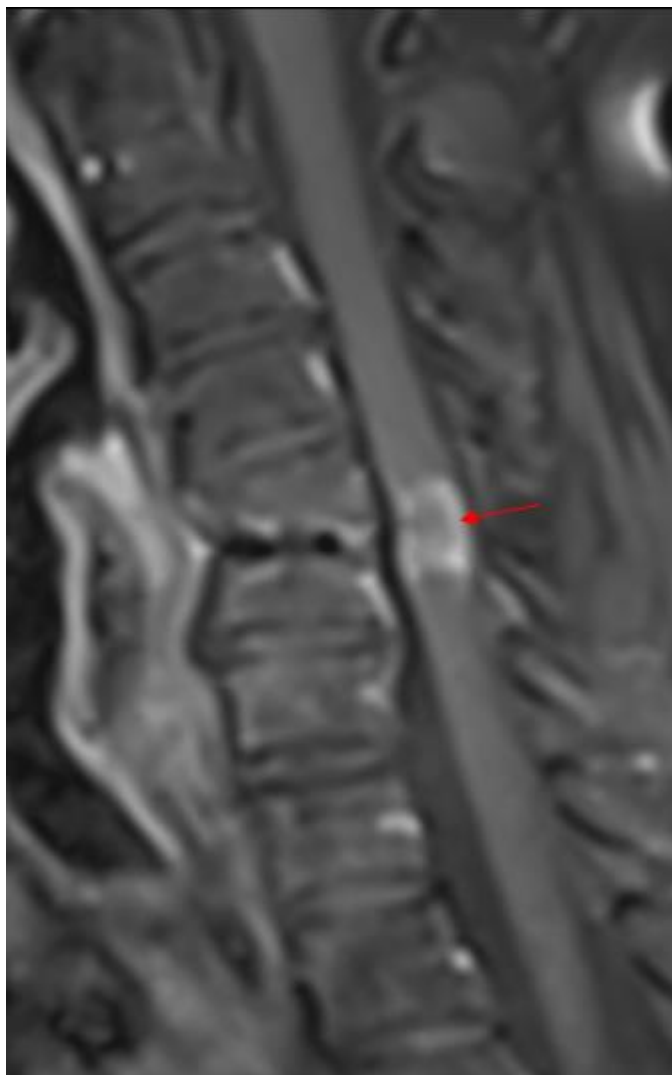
Sagittal T1-weighted post-gadolinium MRI. The sequence reveals patchy, ill-defined contrast enhancement localized at the C5–C6 level (red arrow) corresponding to the active tumor core of the intramedullary neoplastic lesion..
